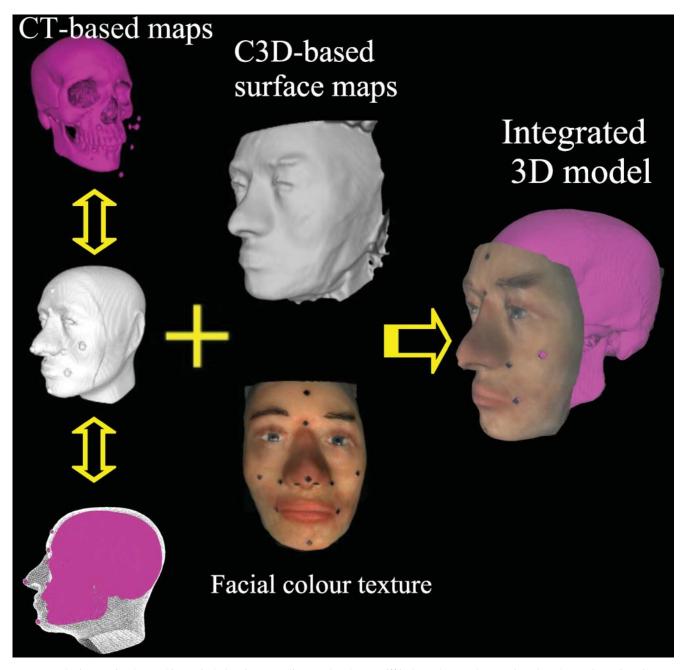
The future of orthognathic surgical planning according to Khambay *et al.*¹⁶ is dependent on the use of CT-based maps in conjunction with stereophotogrammetry.
